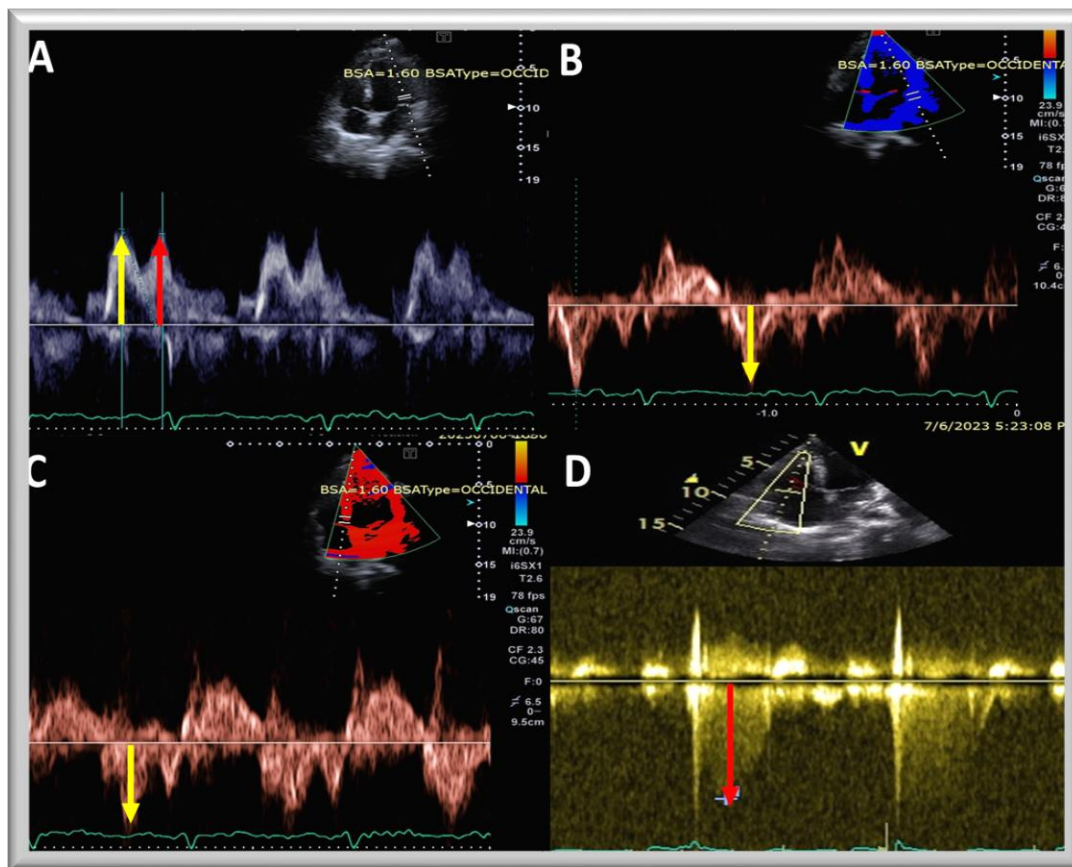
Diastolic function parameters on echocardiography. A- mitral E and A wave, B and C- lateral wall and septal e' and D- TR velocity.
